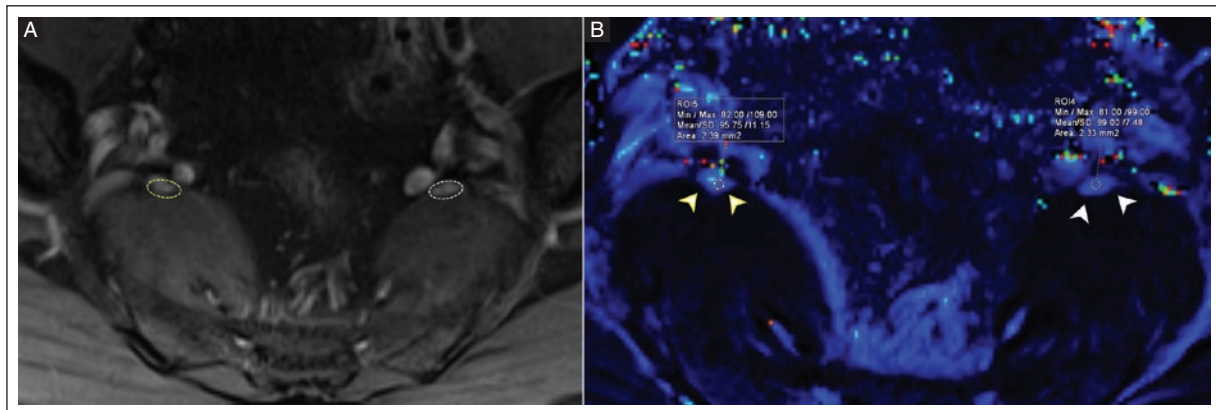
Axial MRI at the level of the piriformis muscles. A: T2 relaxometry multi-echo sequence (TR = 2400 ms; TE = 10 ms) showing the right (yellow dashed circle) and left (white dashed circle) sciatic nerve with homogeneous hyperintensity and normal appearing hypointense fascicles. B: T2 relaxometry color map showing a ROI of 2.39 mm² in the right sciatic nerve with a mean 97.75 ms T2 relaxation time (yellow arrowheads) and a 2.33 mm² ROI in the left sciatic nerve with a mean 89 ms T2 relaxation time (white arrowheads).
